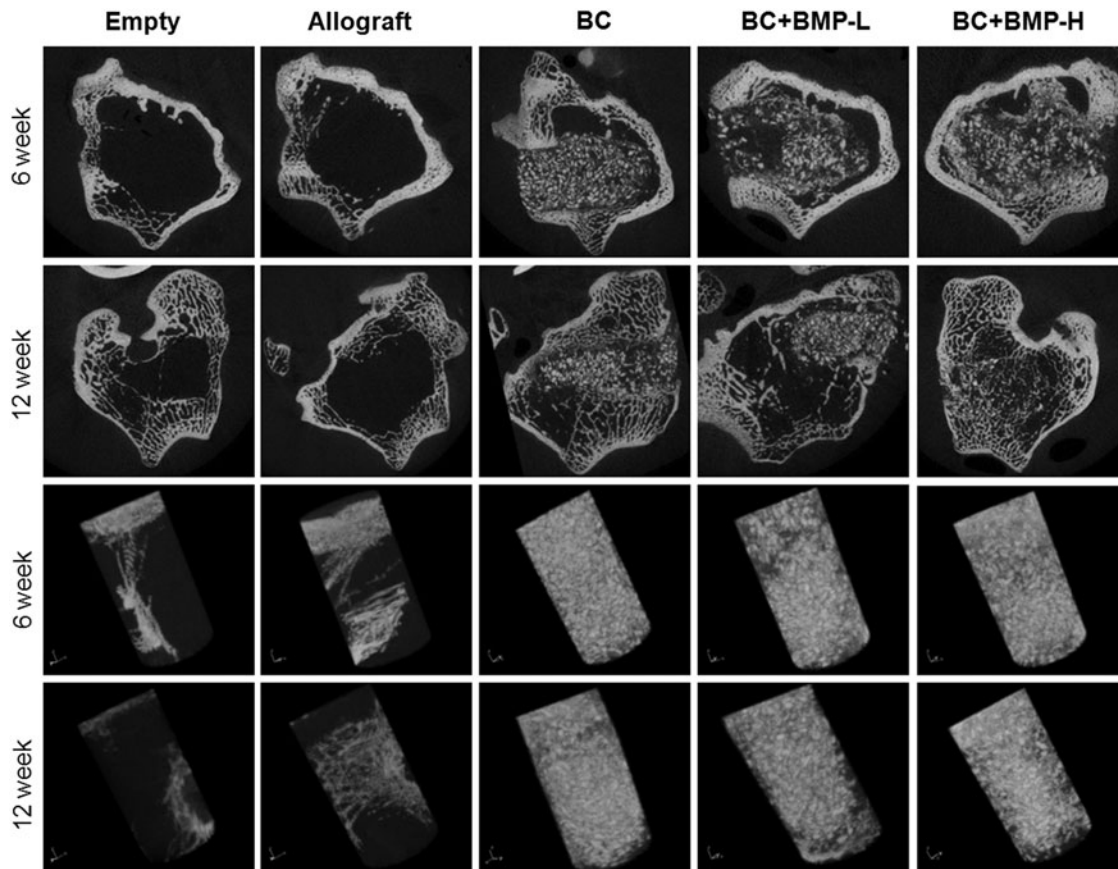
Representative micro-computed tomography (μ CT) images of the empty defects and defects filled with the allograft bone particles, BC, BC + BMP-L, and BC + BMP-H at 6 and 12 weeks. Presented in (A) longitudinal sections of the femur and (B) as three-dimensional reconstructions of the cylindrical defect region of interest. BMP, bone morphogenetic protein.
